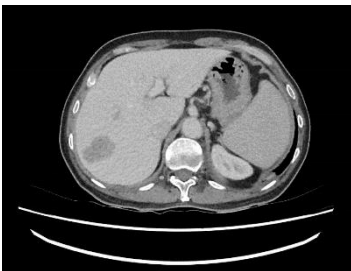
Venous phase of computed tomography scan of the liver, the lesion in segment VII remains hypodense relative to liver.
